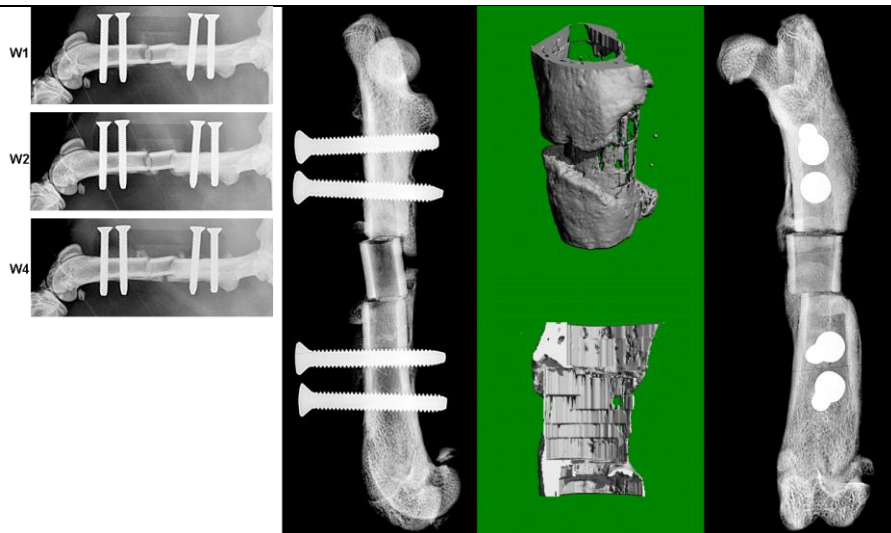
In vivo radiographs, ex vivo radiographs and μ CT scans for 8 week time point
